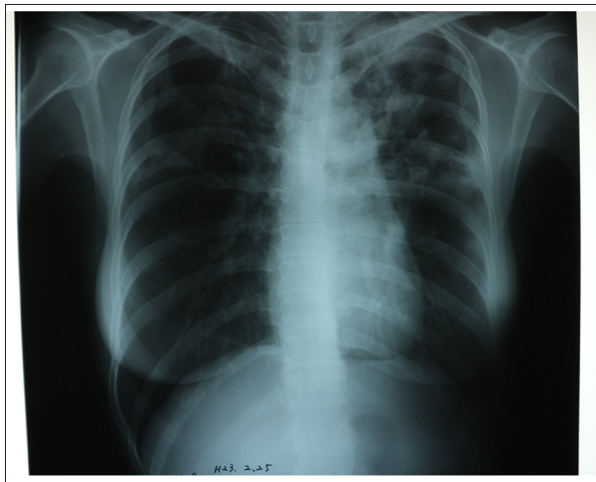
Roentgen photograph. Roentgen photograph shows a borderless, cloudy, wandering shadow-like appearance of the peripheral lung area. Pulmonary function of eosinophilic pneumonia showed a restrictive pattern, indicating that the drug in its aerosol form cannot reach the peripheral lung area. This may be the reason for the ineffectiveness of the inhaled steroids.
